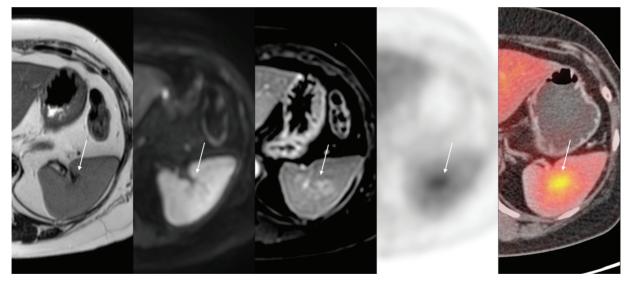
Focal fluorodeoxyglucose (FDG) uptake adjacent the splenic hilum with mild enhancement without any signal alteration on T2-weighted/diffusion-weighted (DW) images.
